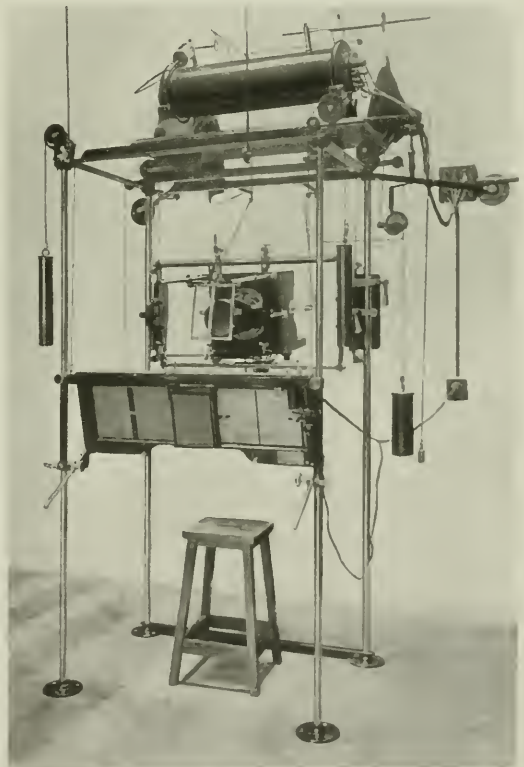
Arrangement of apparatus for radiography of the orbit and accessory sinuses. Fitted with quick-changing stereoscopic movement. (F. Butt & Co.)
